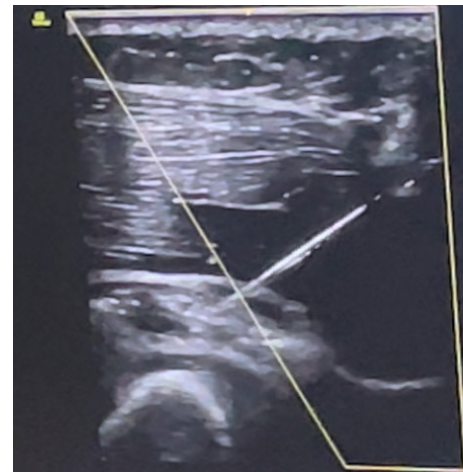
Hydrodissection of PIN in radial tunnel(Ultrasound guided)
